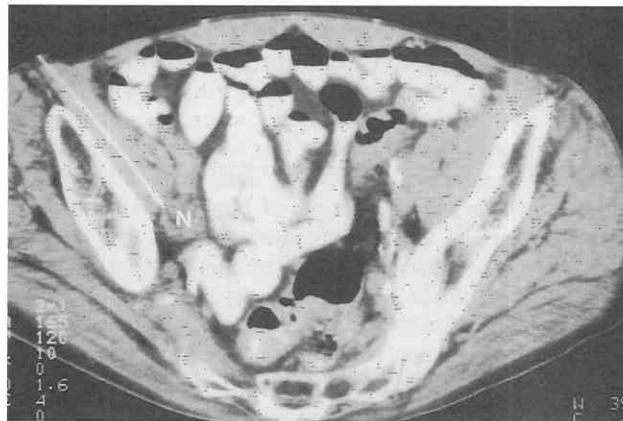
Lymph node biopsy. CT scan during fine-needle aspiration of right hypogastric nodal (N) metastasis from recurrent bladder cancer.
